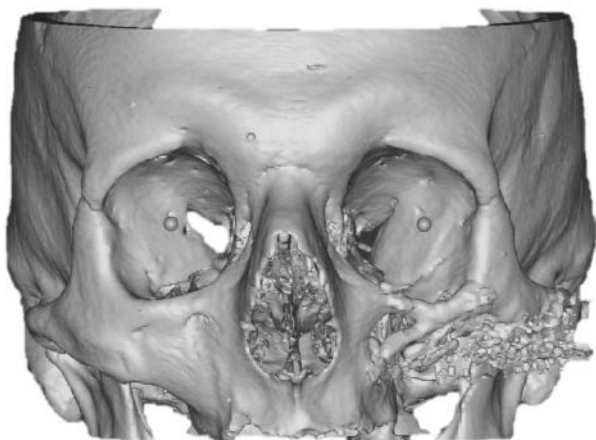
Pre-operative CT-scan of the patient.
